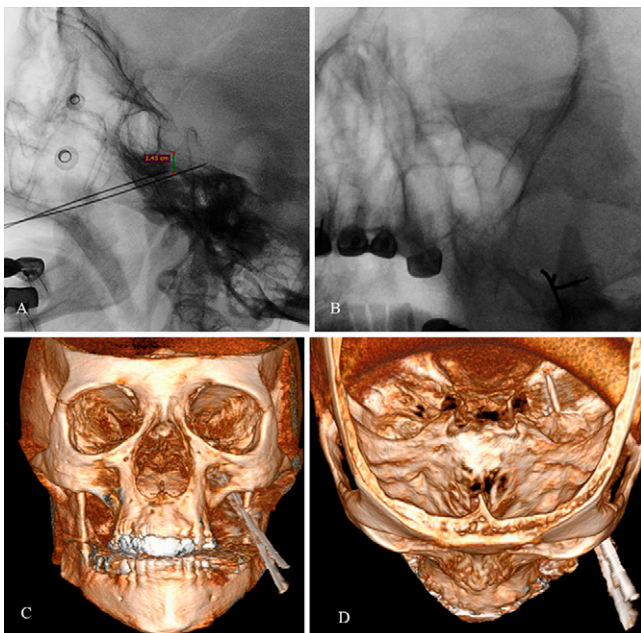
Real-time CT fluoroscopy. A: Sagittal projection. B: Frontal projection. C: 3D CT reconstruction of the needle positioning in the frontal projection. D: 3D CT reconstruction of the needle tip positions.
